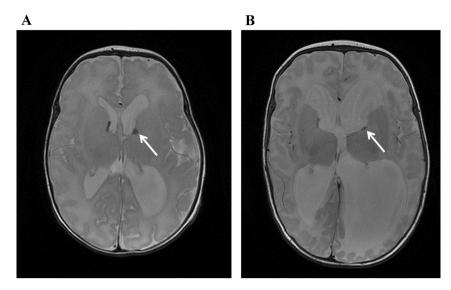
T2 weighted magnetic resonance imaging on 34-day-old (A) and on 84-day-old (B). Arrows indicate mild subependymal hemorrhage (Grade I).
